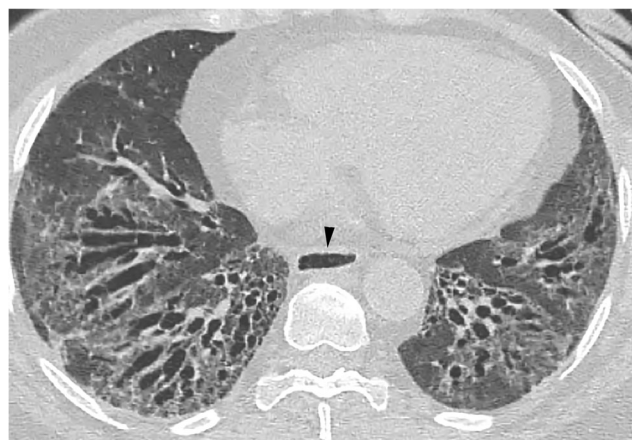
HRCT of a patient with scleroderma shows basal predominant ground-glass opacity, reticular abnormality, and traction bronchiectasis consistent with an NSIP pattern. The esophagus is also patulous (*arrowhead*). Note that bronchiectasis is out of proportion to the remaining fibrotic changes. HRCT high-resolution computed tomography, NSIP nonspecific interstitial pneumonia
